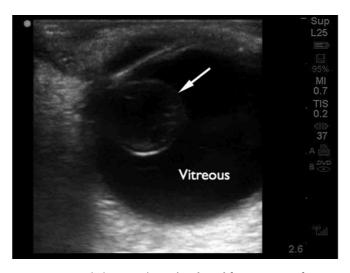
Lens dislocation (arrow). Adapted from Figure 3 of Frasure SE, Saul T, Lewiss RE. Bedside ultrasound diagnosis of vitreous hemorrhage and traumatic lens dislocation. Am *J Emerg Med*. 2013;31(6):1002.e1–e2
